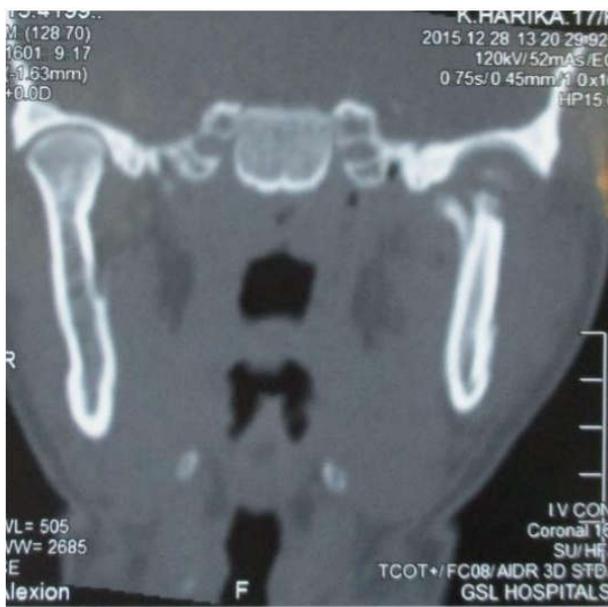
Coronal view of CT reveals destruction of left condyle
